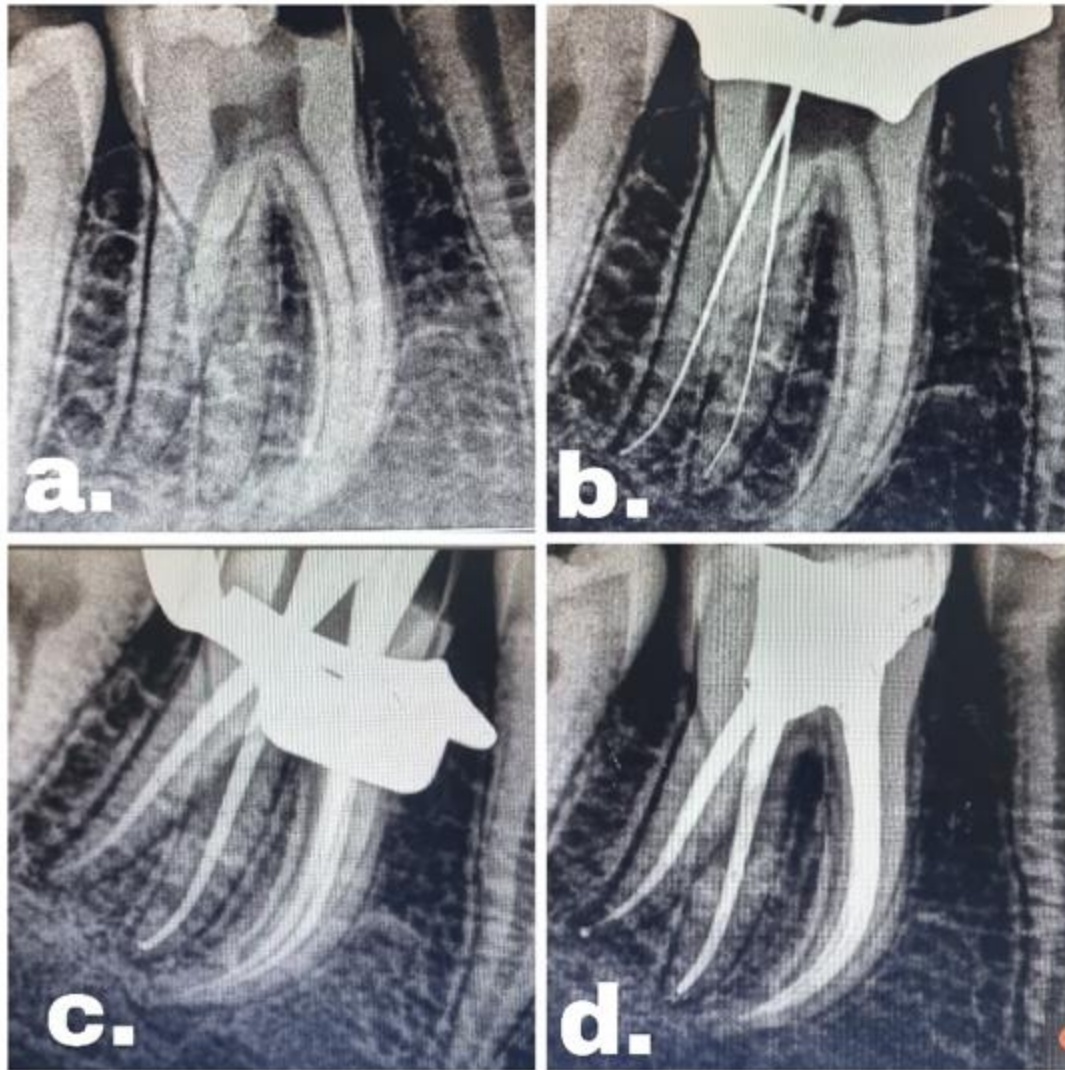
a: Preoperative radiograph, b: Working length determination, c: Master cone radiograph, d: Obturation with post endodontic restoration
